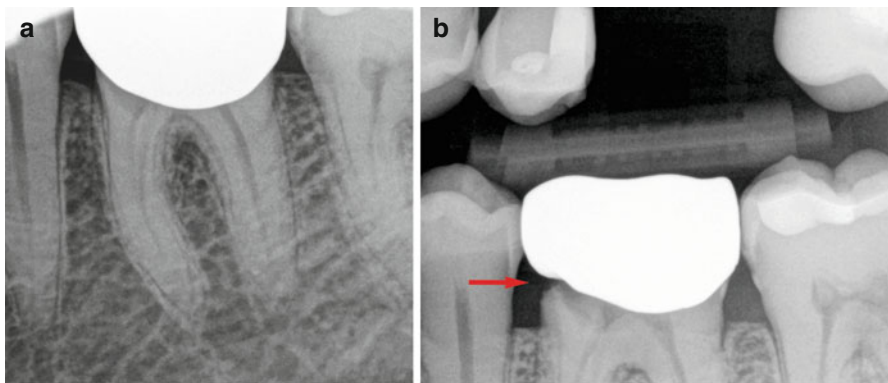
(a) Periradicular radiograph of a mandibular first molar tooth. (b) Bitewing radiograph of the same tooth; note the marginal defect of the crown and associated caries on the mesial aspect of the tooth; (*red arrow*)
